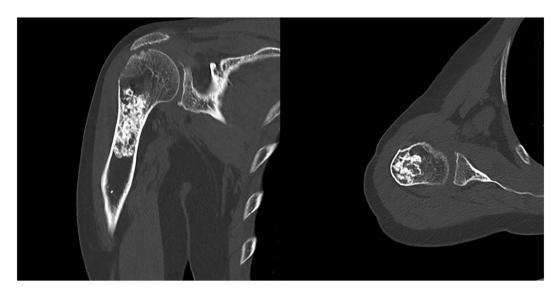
Coronal and axial computed tomography scans demonstrating articulation between acromion and humeral head as well as proximal humerus enchondroma.
